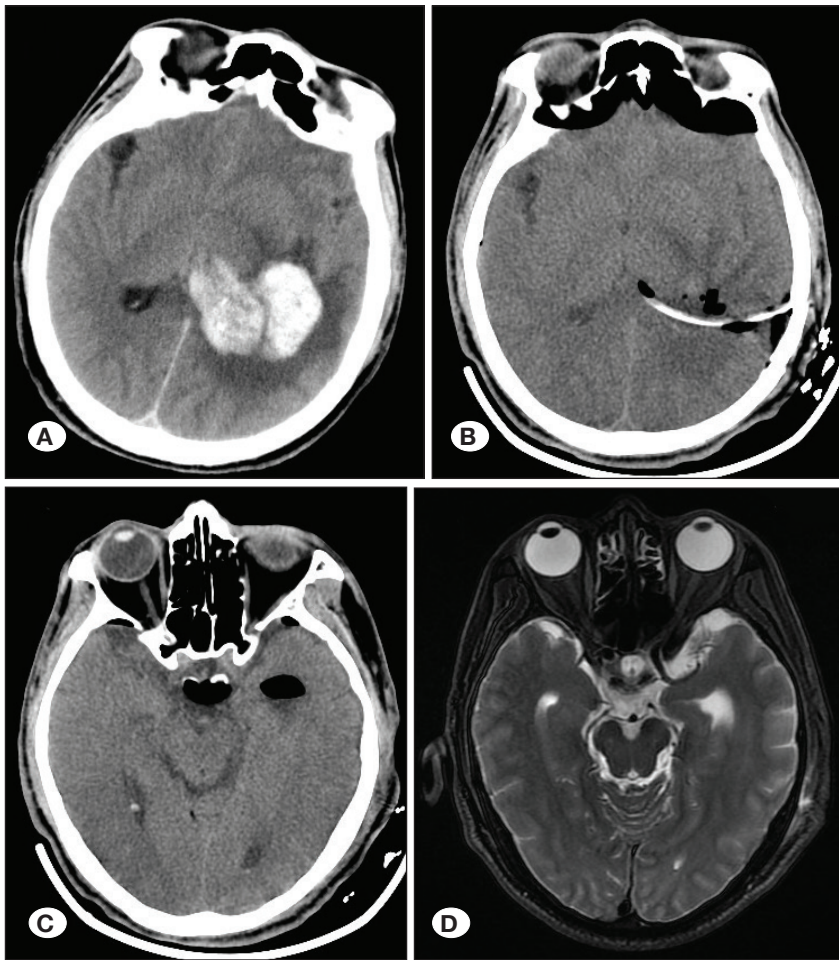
A) Preoperative CT. B) CT re-examination on the day following operation. C) CT re-examination on postoperative day 3. D) MRI re-examination before discharge.
